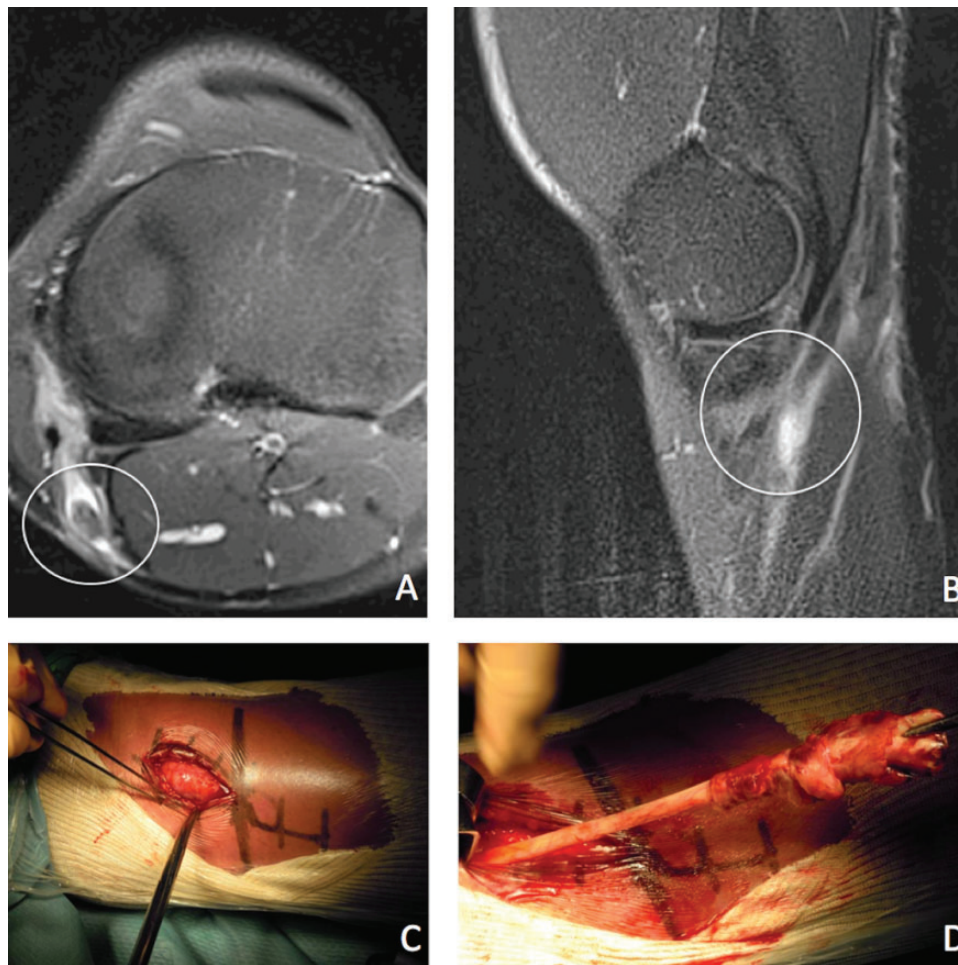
Distal lesion. (A) Coronal and (B) sagittal magnetic resonance images demonstrating distal avulsion of the semitendinosus. (C) Incision and identification of the tendon. (D) Stripping of the tendon.
